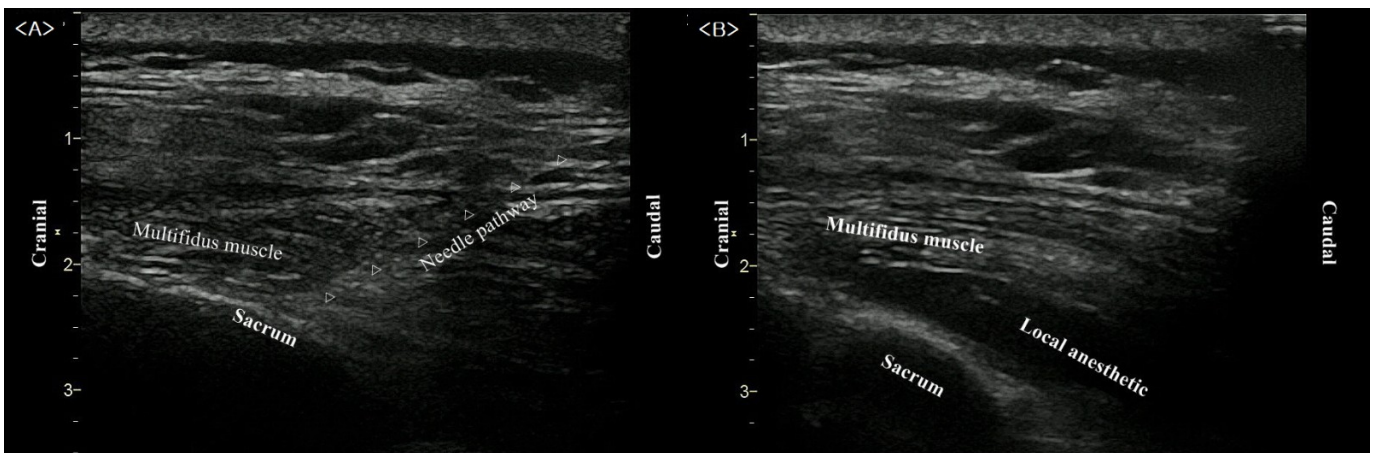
Ultrasound image of the sacral multifidus plane block. (A) Needle pathway toward the sacrum in a caudocranial direction. (B) Upward lifting of the multifidus muscle after injecting local anesthetics.
